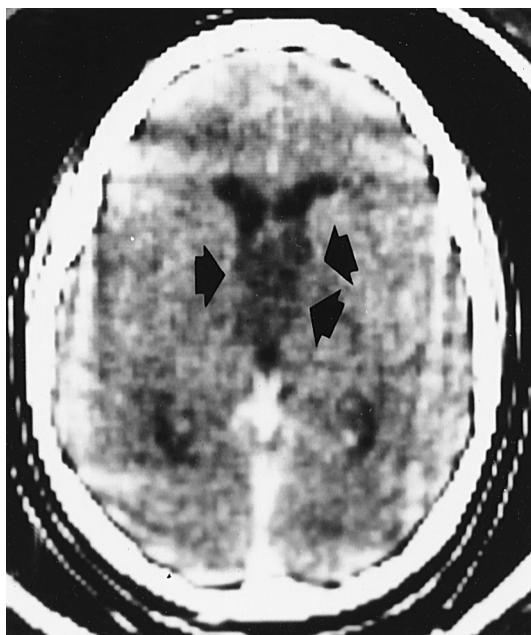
Computed tomography of the brain of a 16-year-old girl with hypothalamic astrocytoma. The low-density tumor mass (arrows) extends superiorly from the hypothalamus, obliterates the third ventricle, and partially compresses the frontal horns of the lateral ventricles (particularly the right). This patient presented with secondary amenorrhea. Menarche had occurred at age 13 years, and menses were normal until 15.3 years. The patient then became amenorrheic in association with lethargy, episodic headaches, polyuria, and weight gain—despite little change in appetite. Physical examination was negative. The skull radiograph, electroencephalogram, visual fields, and serum prolactin and thyroxine levels were normal—and urine-specific gravity was 1.016. After biopsy of the cyst wall, studies revealed her to have gonadotropin, growth hormone, and partial antidiuretic hormone deficiencies.
